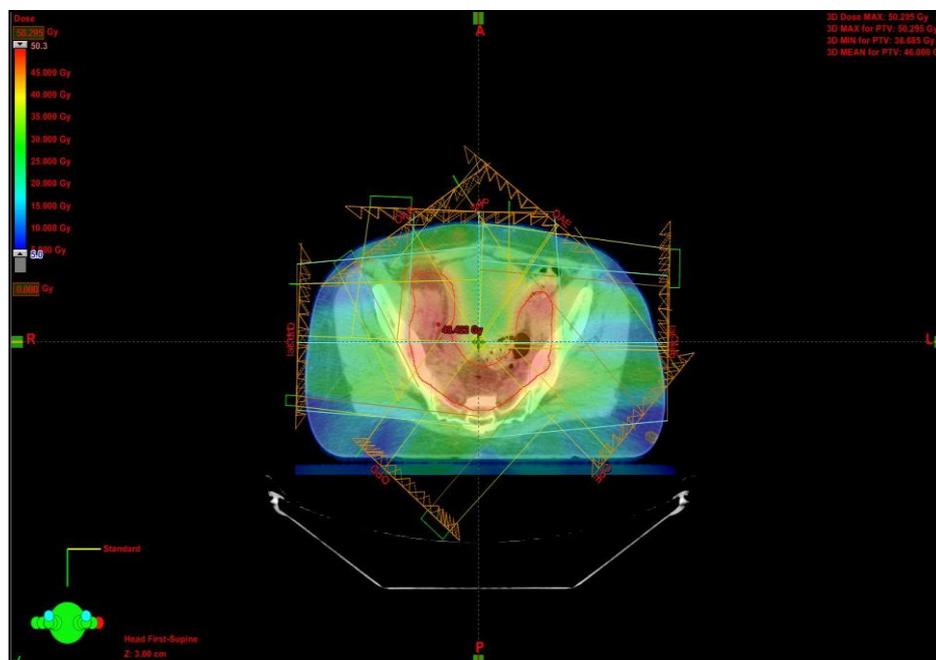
Axial planning CT slice showing dose distribution of pelvis, with IMRT technique.
